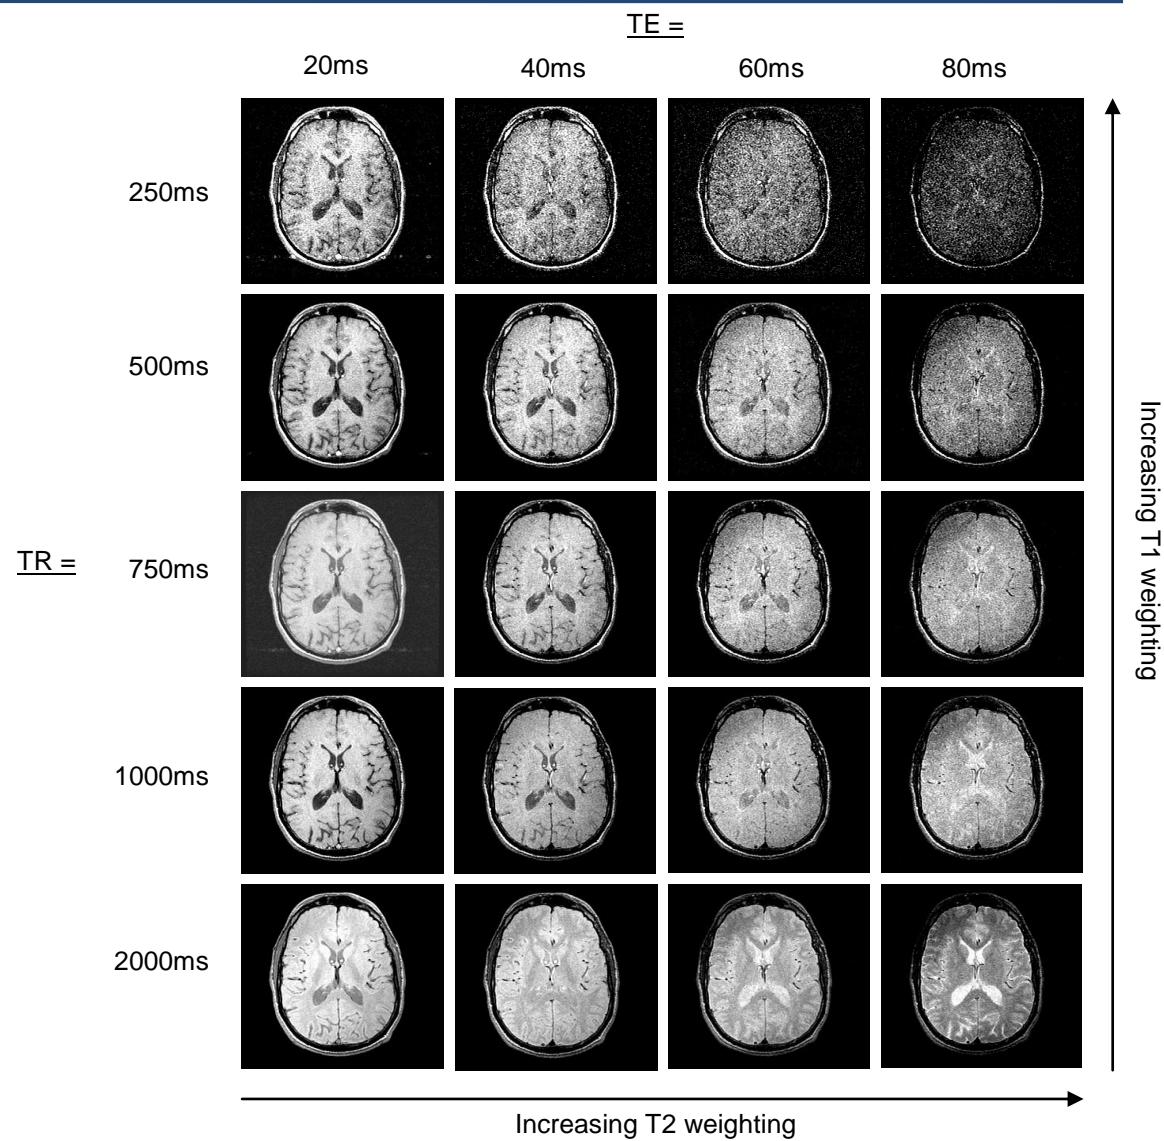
MRI TR/TE relaxation ratios & image contrast
